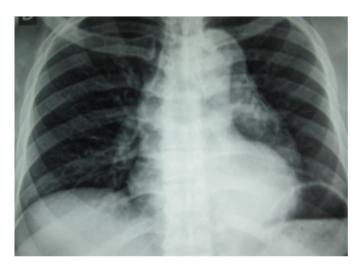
Chest radiograph showing a dilated and calcified aorta
